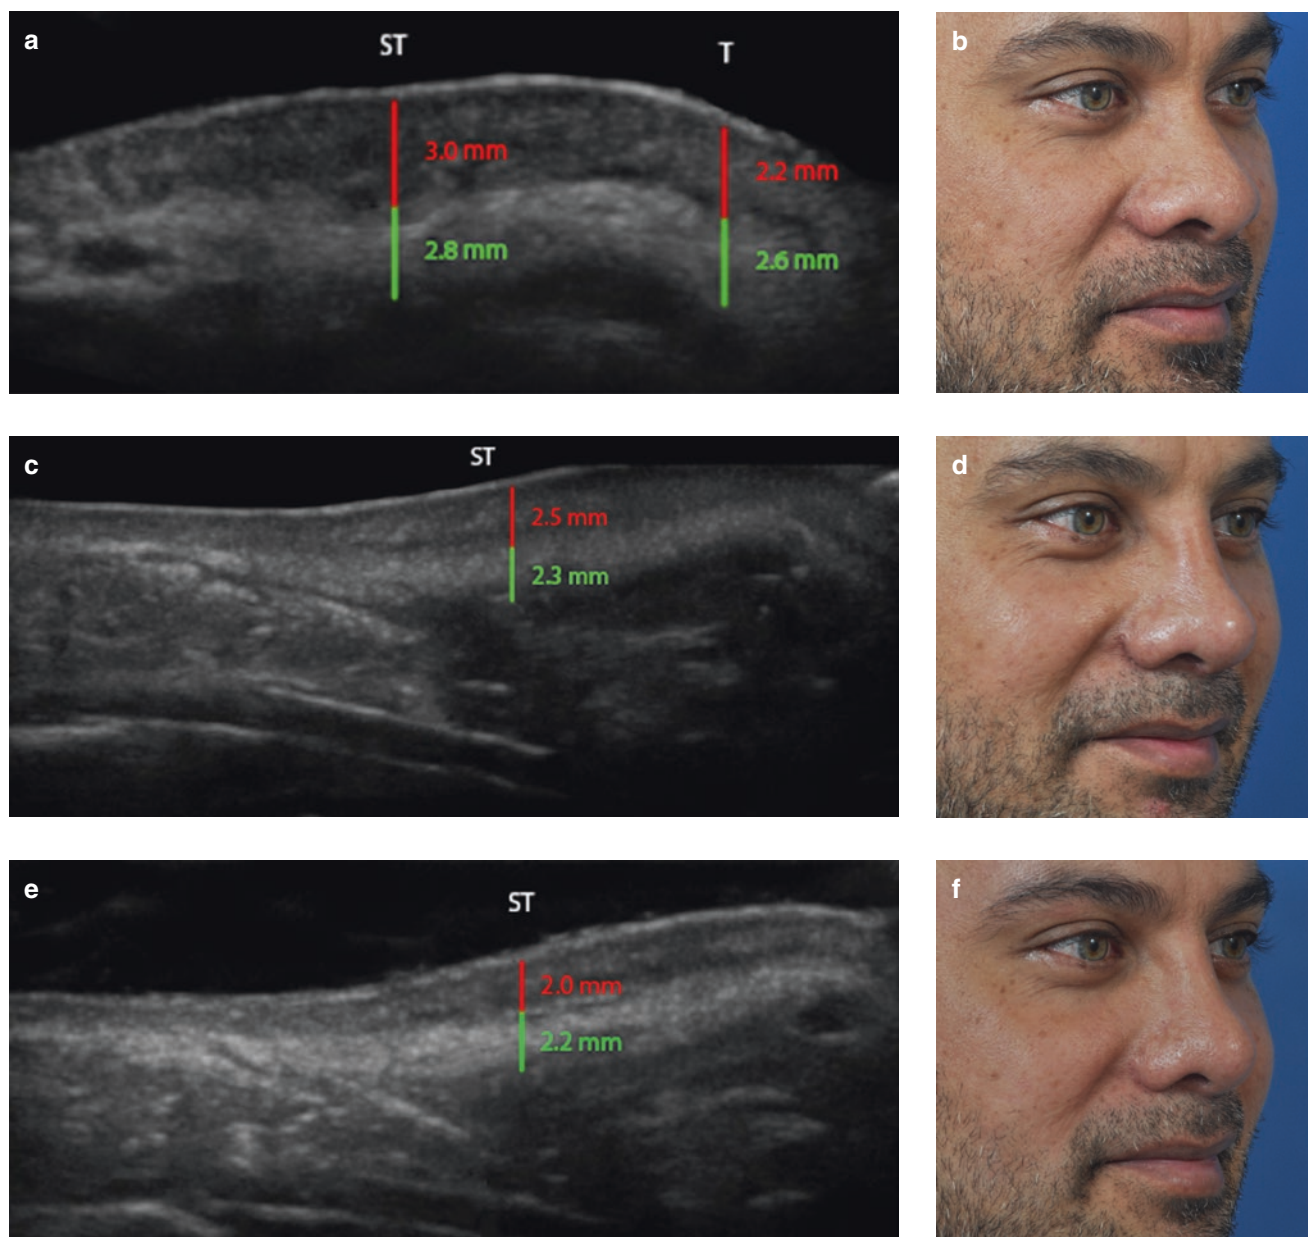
Patient with a thick-skin STE composed of a thick lower part and thin upper part. (a, b) Preop sonogram and photo. (c, d) Views 4 weeks postop, prior to start of Accutane®. (e, f) Views 4 months after surgery and 3 month course of Accutane. The vertical measurements show dermis (red) and SMAS (green). Note: there has been a full 1 mm thinning of the dermis (33%) and 0.6 mm of the deep soft tissue (25%). ST supratip; T tip
